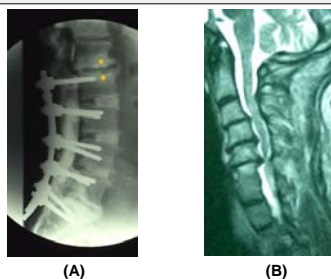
(A) A radiograph of a rigid five level (L2 to sacrum) instrumented fusion. Yellow dots are placed on the thickened and sclerotic end plates of the degenerated segment adjacent to the fusion. (B) Sagittal magnetic resonance image revealing previous C6-7 fusion with development of new adjacent level disease above the fused segment [1].
